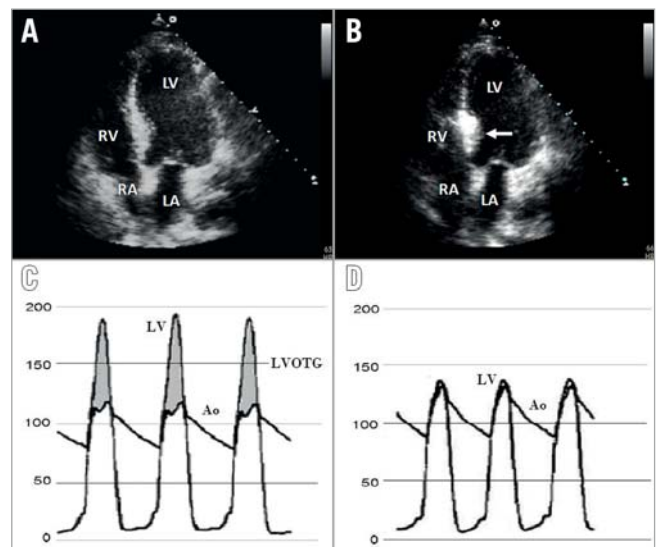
Periprocedural monitoring. A) Transthoracic echocardiography before ASA showing asymmetric septal hypertrophy. B) Localisation of echo contrast (thick arrow) in the basal septum in apical four-chamber view. Cardiac catheterisation pressures showing the LVOTG between the LV and aorta before (C) and after ASA (D). Ao: aorta; LA: left atrium; LV: left ventricle; LVOTG: left ventricular outflow tract gradient; RA: right atrium; RV: right ventricle
